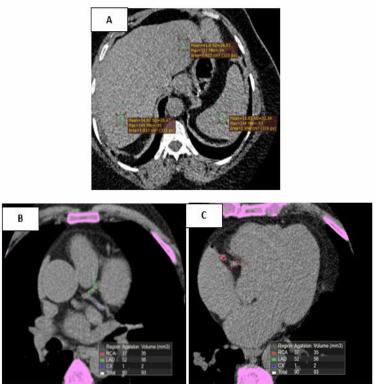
A: An axial non contrast enhanced CT image at the upper abdomen demonstrates mildly low attenuation of the liver in comparison to the spleen (Right hepatic lobe= 54.9 HU, left hepatic lobe= 41.9 HU and spleen= 53.8 HU), with hepatic to splenic ratio=0.94. B & C: Axial non contrast enhanced image of coronary calcium scoring showing mild coronary arterial atherosclerotic calcifications with Agatstone score= 90
